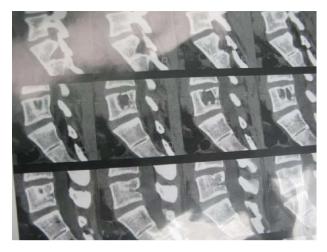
Case 2, CT- scan of L5 vertebrae.
